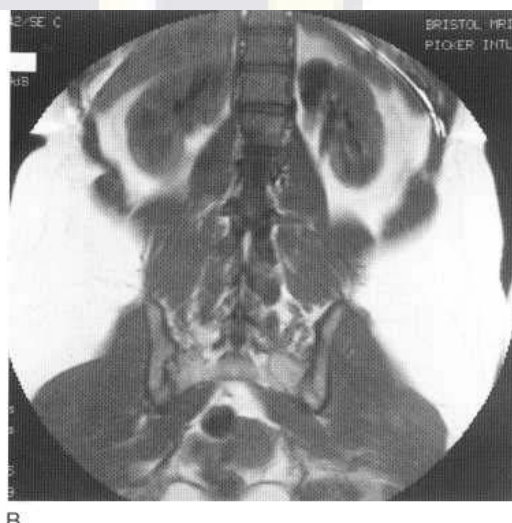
(A) Ultrasound of duplex kidney with upper pole moiety hydronephrosis; there has been virtually complete loss of cortex from the upper pole moiety. Similar features seen on MRI in a different patient with a small, chronically hydronephrotic upper pole moiety (B).
